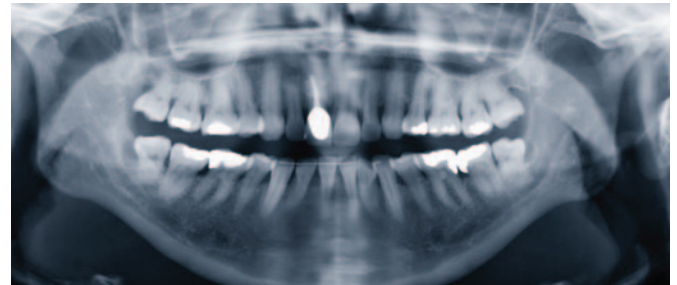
(ABOVE): Orthopantomogram (OPG) of patient taken at initial periodontal assessment.
